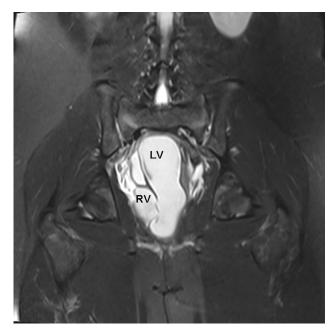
T2-weighted, fat-saturated coronal view of the pelvis demonstrates the dilated right vagina (RV) and the more dilated left vagina (LV).
